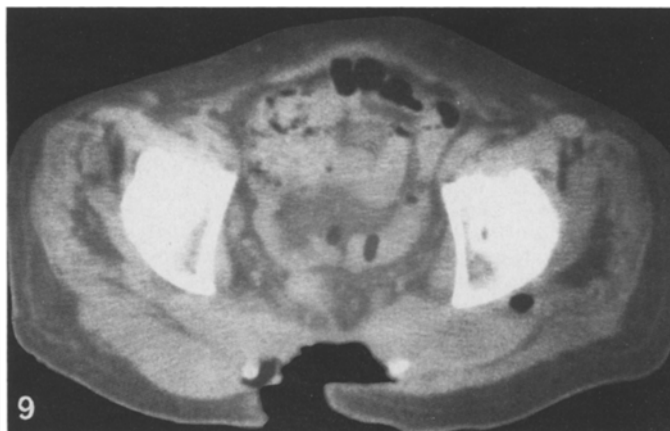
CT. Deep ulceration through soft tissues at site of bone destruction. Small bony fragments remain. This on biopsy represented a giant and spindle cell sarcoma – a new tumor – almost certainly a radiation-induced sarcoma
